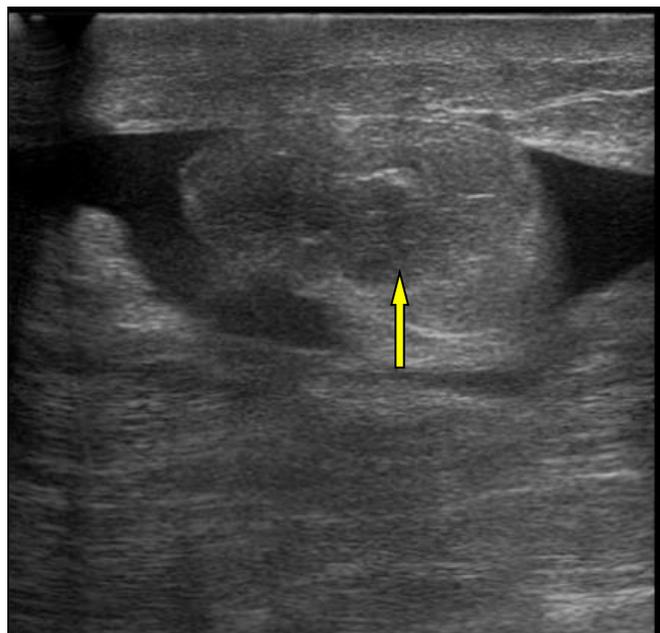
Ultrasound images (Siemens Antares sonography unit, Siemens Medical Solutions, Sweden) at six-month follow-up in three patients treated by breast oncoplastic conservative surgery with ORC. With the use of a high-frequency 10–13 MHz linear array transducer, a free anechoic collection without wall with the presence of typical small hyperechoic round masses (yellow arrow) in continuity with the breast parenchyma is showed.
